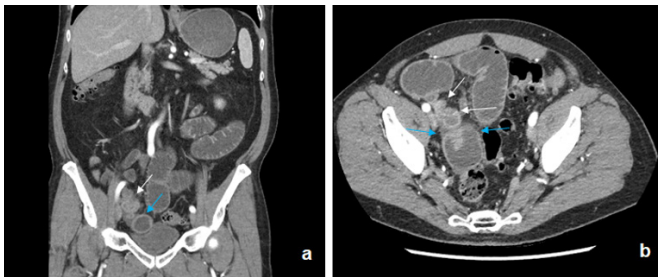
CT abdomen pelvis performed during admission for SBO. (A) Coronal slice. (B) Axial slice. The distal appendix (white arrows) is markedly dilated and adherent to the distal ileum (blue arrows). Significant dilation of the small bowel can be seen proximal to the RLQ transition point.
